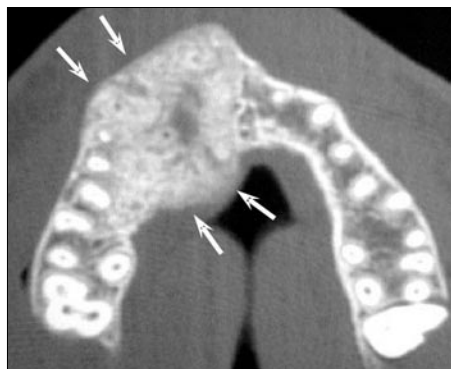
CT image (axial view) of a fibrous dysplasia showing a unilateral, ill-defined and radiolucent-radiopaque lesion (courtesy of Dr. Roman Carlos, Centro de Medicina Oral de Guatemala).
